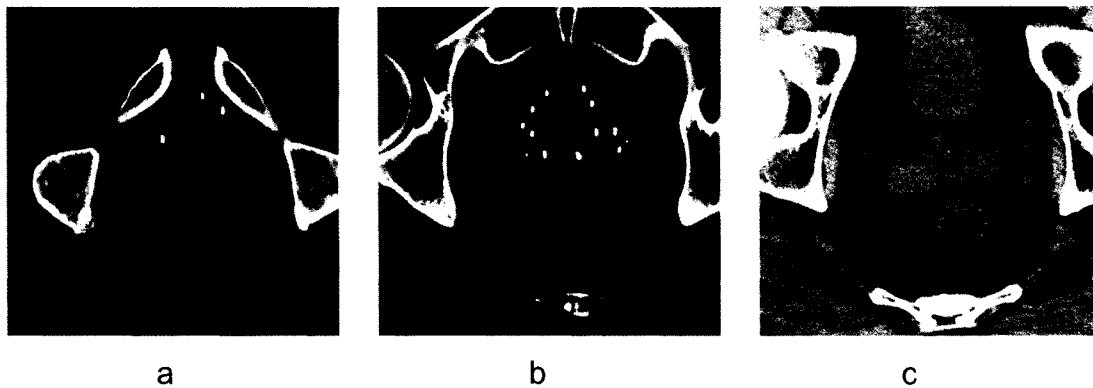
CT image volume of a prostate implant: a) caudal slice, b) mid-gland slice, c) cranial slice.
